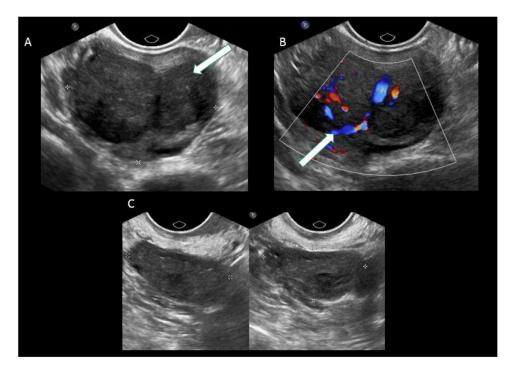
(A) Ultrasonography image showing a well-defined lobulated hypoechoic lesion (white arrow) in right ovary with displacement of normal ovarian parenchyma. (B) Doppler image showing predominant peripheral vascularity (white arrow) on Doppler study. (C) Ultrasonography image showing normal left ovary in 2 dimensions.
